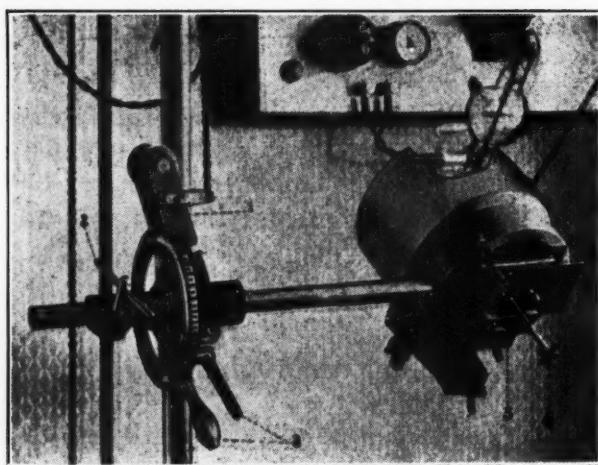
Cieszyński's tubestand with anglo-meter for shifting and inclining the x-ray tube.
